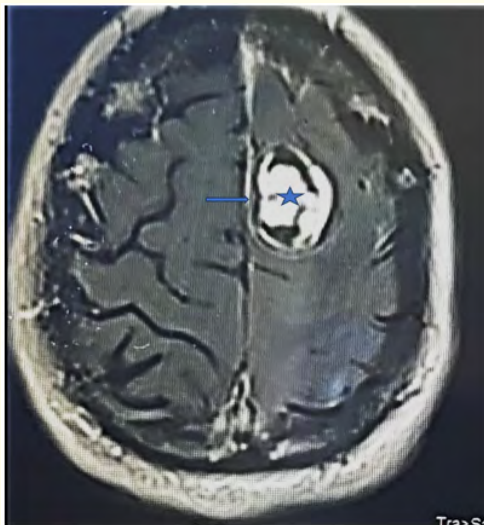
Cerebral magnetic resonance imaging: showing a well-defined parasagittal tumor in his left parietal lobe (star) with attachment to the dura mater (arrow).
